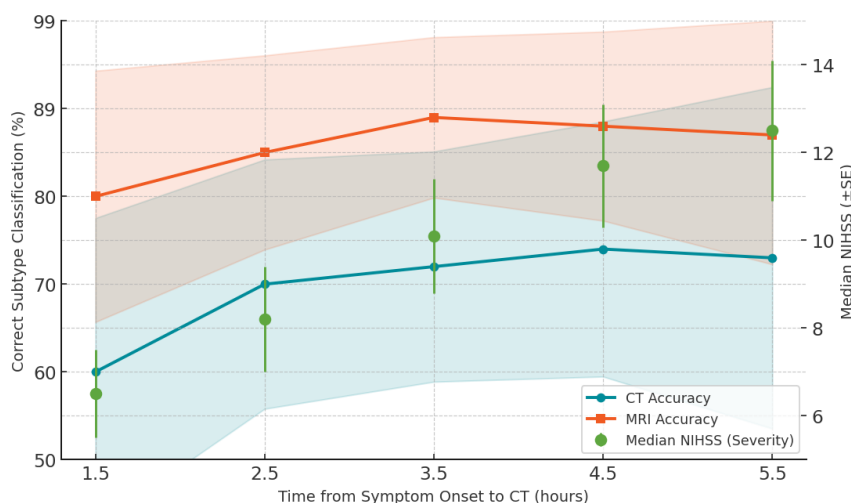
CT and MRI stroke subtype classification
